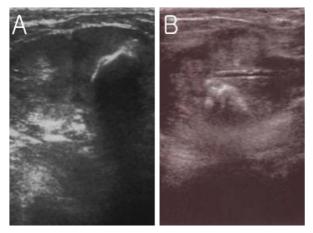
Ultrasonographic transeverse features of prostatic calculus and acoustic shadow in the left prostatic lobe (A). The end of the catheter and protruded calculus is contacted within the prostatic urethra (B).
